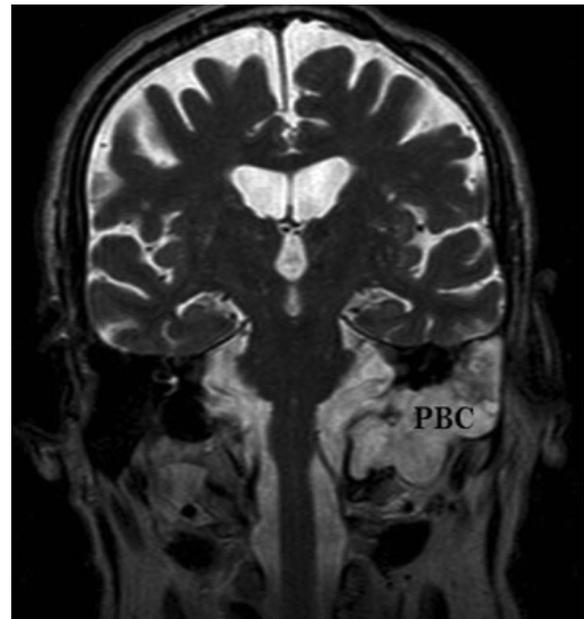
Coronal MRI, T1-weighted sequence; presence of a hyperintense $6 \times 2 \times 3$ cm soft tissue extended between the skull base and the first cervical vertebra. MRI, magnetic resonance imaging; PBC, petrous bone cholesteatoma.
